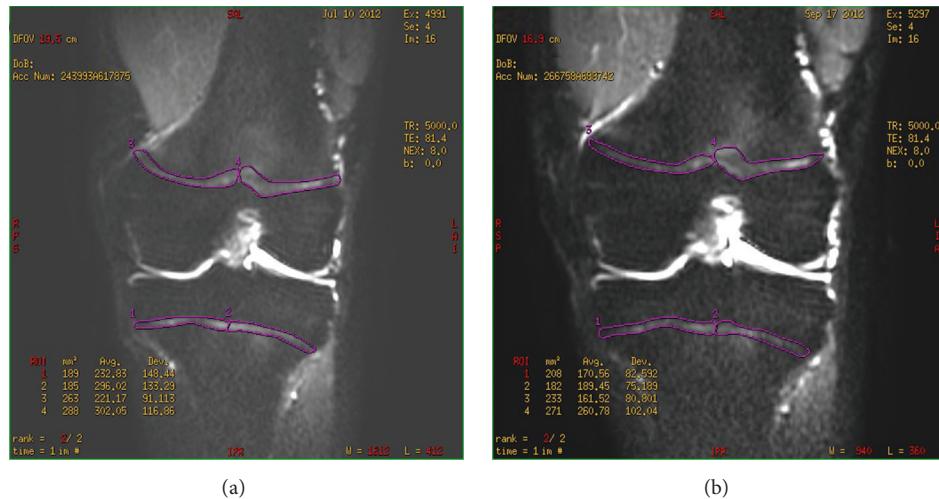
A sample of DWI analysis in a 14-year-old soccer player before (a) and two months after (b) sport activity. First, the coronal surfaces in the most central MRI were encircled (purple line). Each growth plate surface area was then halved to form four regions of interest for the analysis. An apparent diffusion coefficient (ADC) was calculated in each of these regions.
